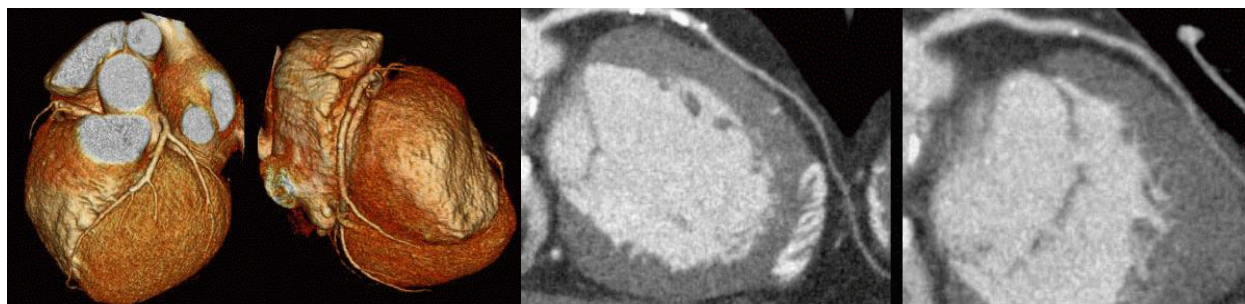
On the left two 3D volume rendering images and on the right two 2D CT coronary angiography scanning.
